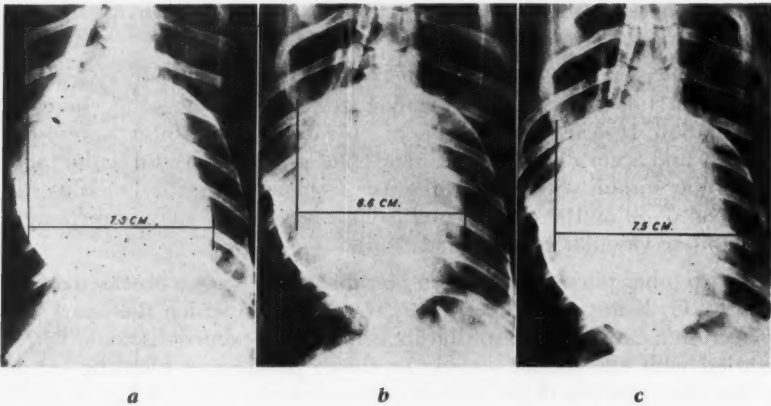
X-ray photographs taken before and during prolonged post-hemorrhagic hypotension. (a), Photograph of roentgenogram taken during prehemorrhagic period. (b), Photograph taken during hypotensive period when cardiometer indicated greatest reduction in cardiac size. (c), Photograph taken just before treatment began. Cardiometer indicated an increase of 3.5 stroke volume units in systolic volume. (Courtesy of SURGERY 16:430, 1944)
